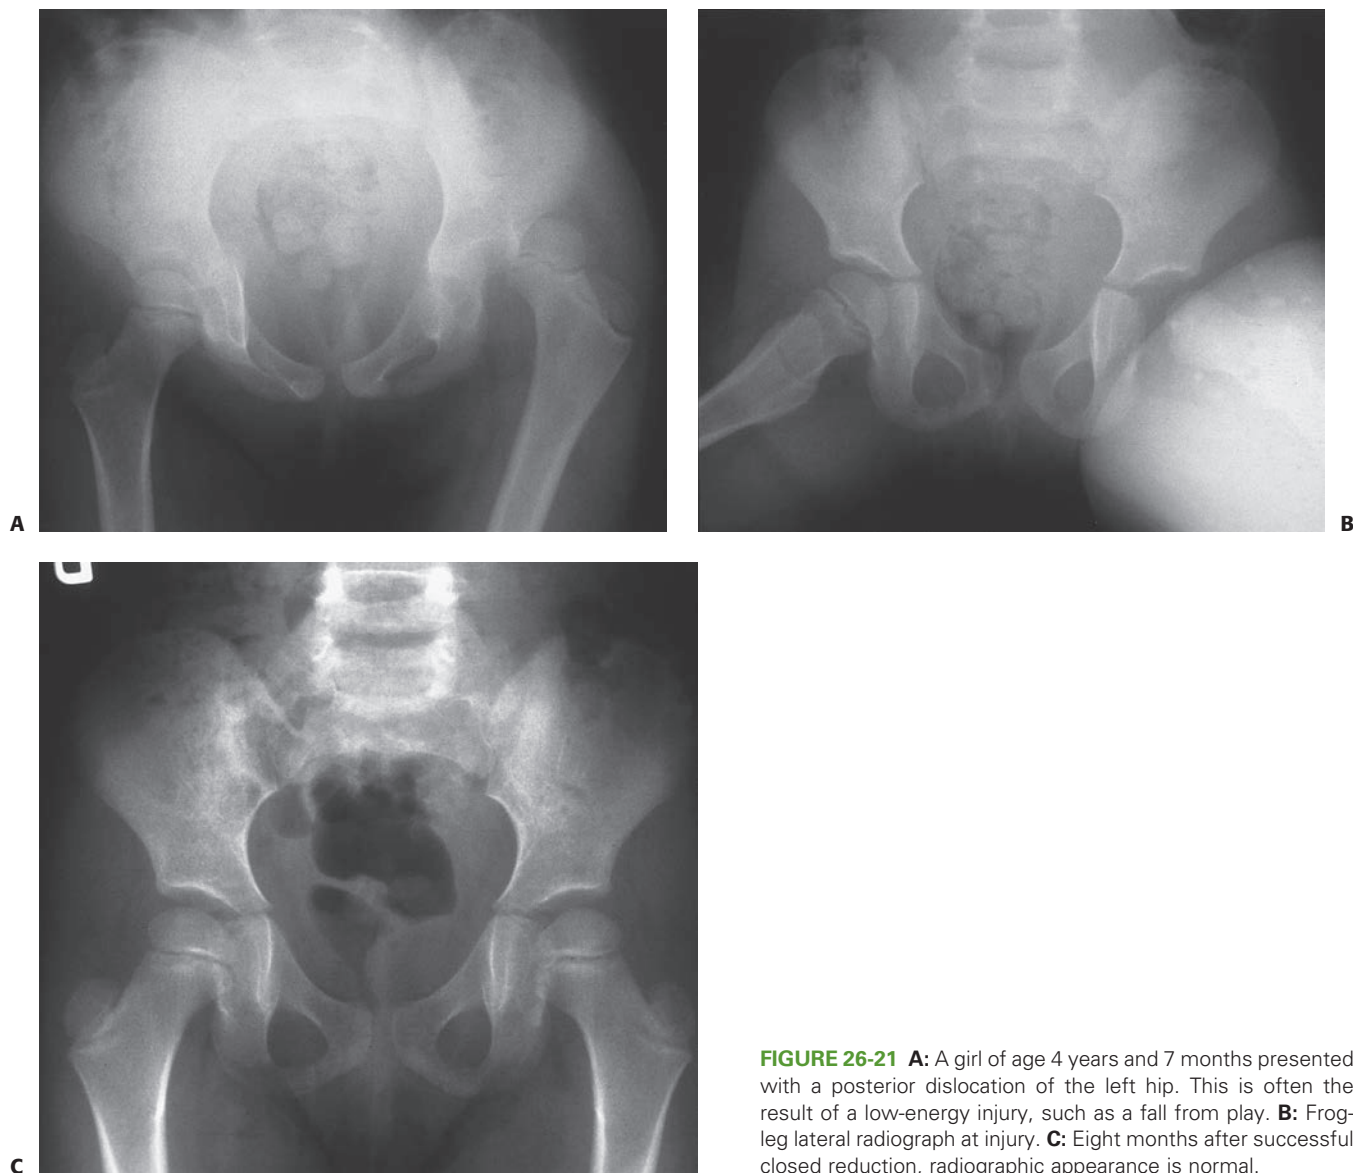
A: A girl of age 4 years and 7 months presented with a posterior dislocation of the left hip. This is often the result of a low-energy injury, such as a fall from play. B: Frog-leg lateral radiograph at injury. C: Eight months after successful closed reduction, radiographic appearance is normal.
